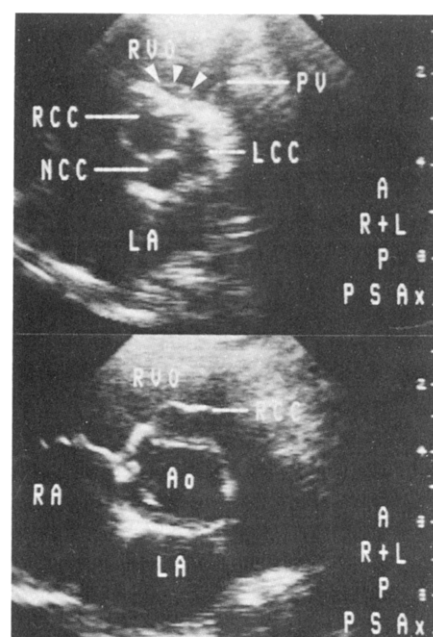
Two-dimensional echocardiographic display of various degrees of aortic valve herniation in two patients with doubly committed subarterial ventricular septal defect. Both frames are shown in the parasternal short-axis (PSAx) view. Top (Patient 16), Diastolic frame demonstrating mild aortic valve herniation. The right sinus and coronary cusp (RCC) are enlarged when compared with the left and non-coronary cusps (LCC, NCC). The herniated part of the right sinus (arrowheads) is depicted in the right ventricular outflow tract (RVO), close to the pulmonary valve (PV). Bottom (Patient 20), Systolic frame showing severe herniation of the right aortic (Ao) sinus. L = left; R = right; RA = right atrium; other abbreviations as in previous figures.
